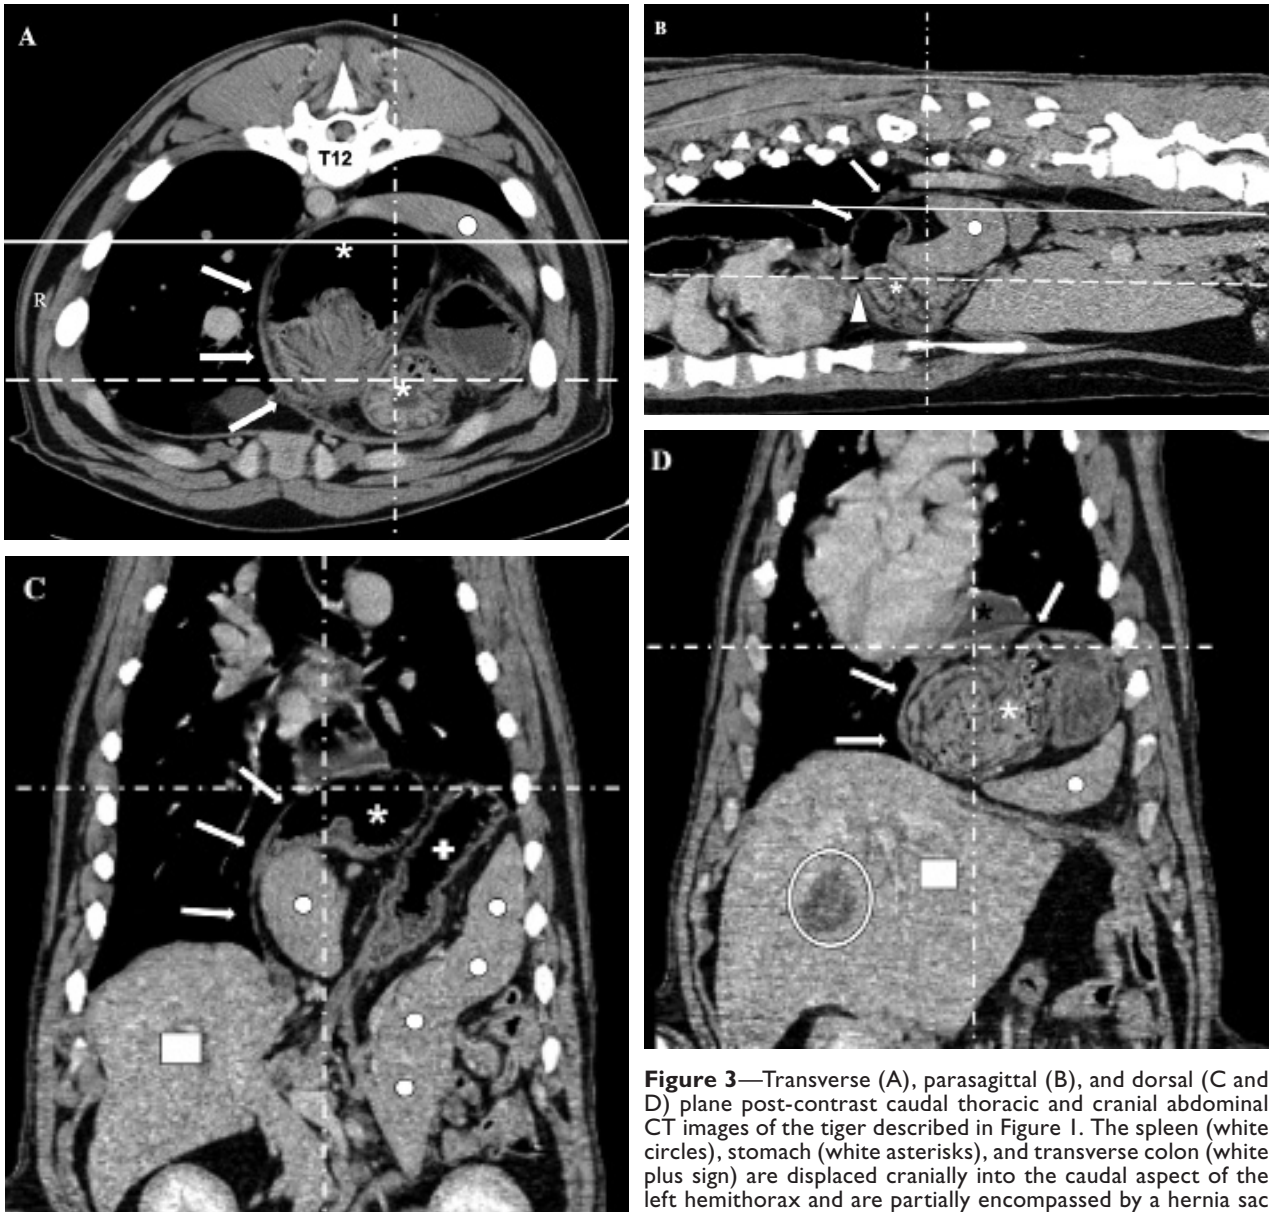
Transverse (A), parasagittal (B), and dorsal (C and D) plane post-contrast caudal thoracic and cranial abdominal CT images of the tiger described in Figure 1. The spleen (white circles), stomach (white asterisks), and transverse colon (white plus sign) are displaced cranially into the caudal aspect of the left hemithorax and are partially encompassed by a hernia sac (arrows). These displaced abdominal organs are causing a contralateral shift of the heart and mediastinum. A small amount of gas is evident at the gastroesophageal junction (arrowhead), and there is fluid in the lumen of the caudal aspect of the esophagus (black asterisk). No abnormalities are seen with the liver (white squares); the hypoattenuating area (encompassed by a circular outline) is considered a normal finding, consistent with the gallbladder. The images are presented in a soft tissue algorithm (window width, 300 HU; window level, 35 HU) with a 1.25-cm slice thickness. The lines across the images represent the planes of the other images, with the 2 dorsal planes distinguished by a solid line (represents the plane of C) and a dashed line (represents the plane of D). The tiger's right side is toward the left (A, C, and D) and its head is toward the left (B) or top (C and D). T12 = 12th thoracic vertebra.
